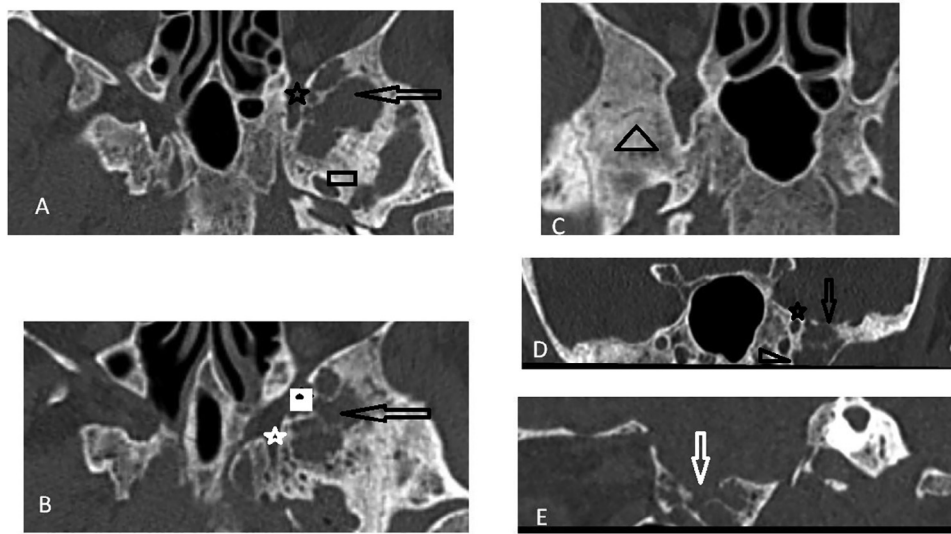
Computed tomography images. Axial images of the abnormal greater wing of the left sphenoid (A and B); axial image of the normal right sphenoid (C, triangle); and coronal (D) and sagittal images of the left sphenoid (E). These images show the lytic, multicystic lesion with focal cortical erosions at bony margins (arrows) on the left. Normal-looking foramen rotundum (star; A, B, and D), foramen ovale (rectangle, A), pterygopalatine fossa (white square, B), and vidian canal (side triangle, D).
